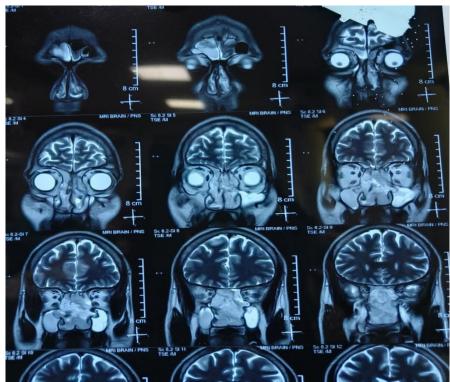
a) Computed tomography (CT) plain of the paranasal sinuses shows a mass involving both nasal cavities. Bony destruction of nasal septum and compression of left lamina payracea is evident. b) Saggital section of CT PNS showing involvement of Frontal, Sphenoidal and Ethmoidal sinuses with intact skull base. c) MRI Brain and PNS showing involvement of B/L nasal cavities, PNS with hyperintensity in left maxillary sinus and right frontal sinus.
